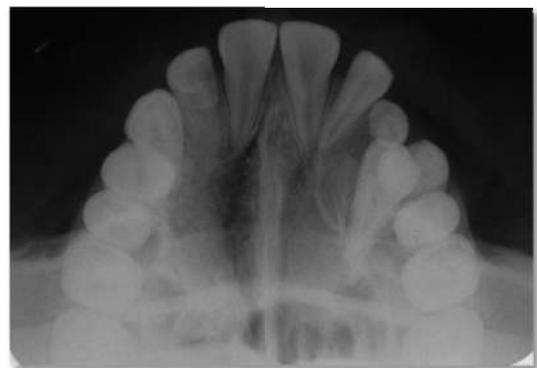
Maxillary cross-sectional occlusal radiograph showing the internal aspect which was moderately radiolucent with displacement of 22
